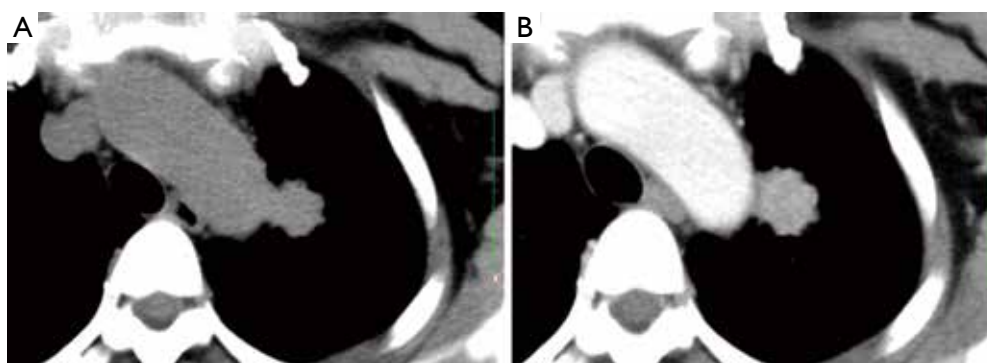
A pulmonary carcinoma (arrow) with enhancement of 37 Hounsfield units after CT contrast agent injection. (A) plain CT; (B) contrast enhanced CT.
